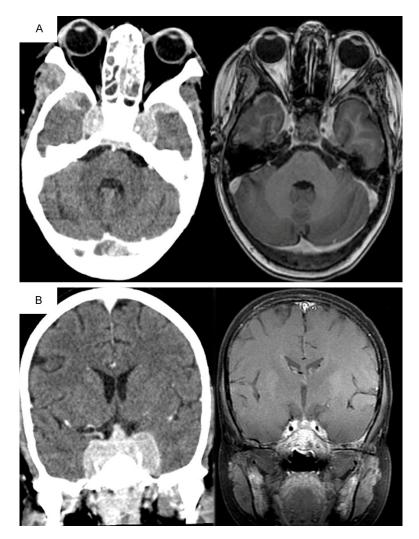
Baseline CECT of the brain showing dura-based soft lesions with complete resolution in end-of-treatment MRI in (A) axial and (B) coronal section.
